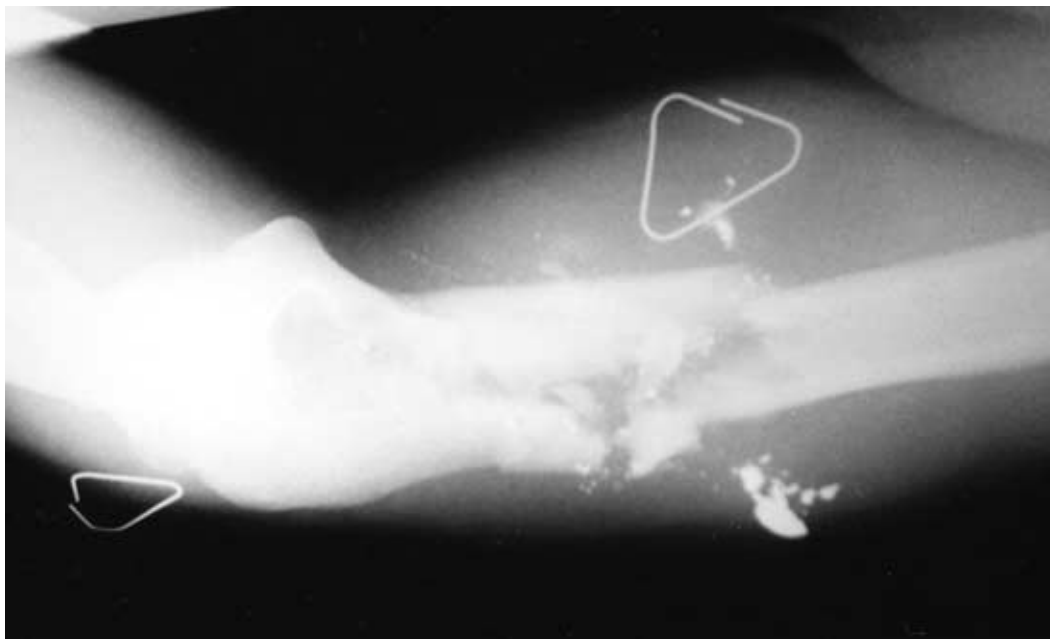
Gunshot wound of the humerus. The patient had a palpable pulse, and vascular injury was not suspected initially. X-ray with the use of radio-opaque markers demonstrated an increased likelihood of vascular injury, which was confirmed on subsequent angiography.
